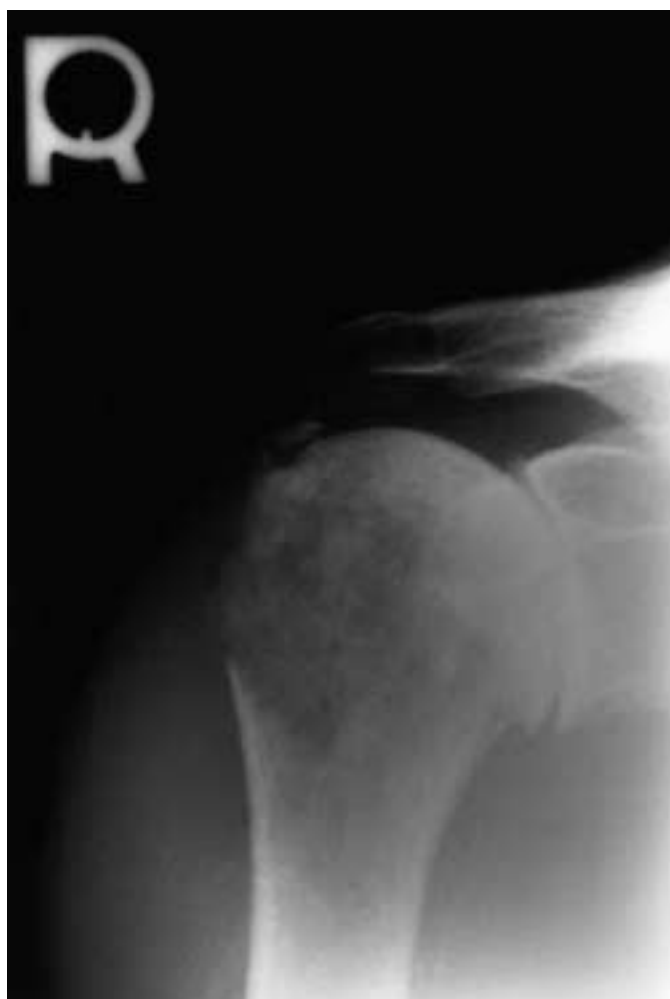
Plain-film radiograph of the right shoulder. Note the large, ill defined, moth-eaten lesion located on the lateral two-thirds of the humeral head (arrows), with destruction and fragmentation of the greater tuberosity (arrowheads). Note the incidental calcific deposit within the supraspinatus tendon (hatched arrow).
